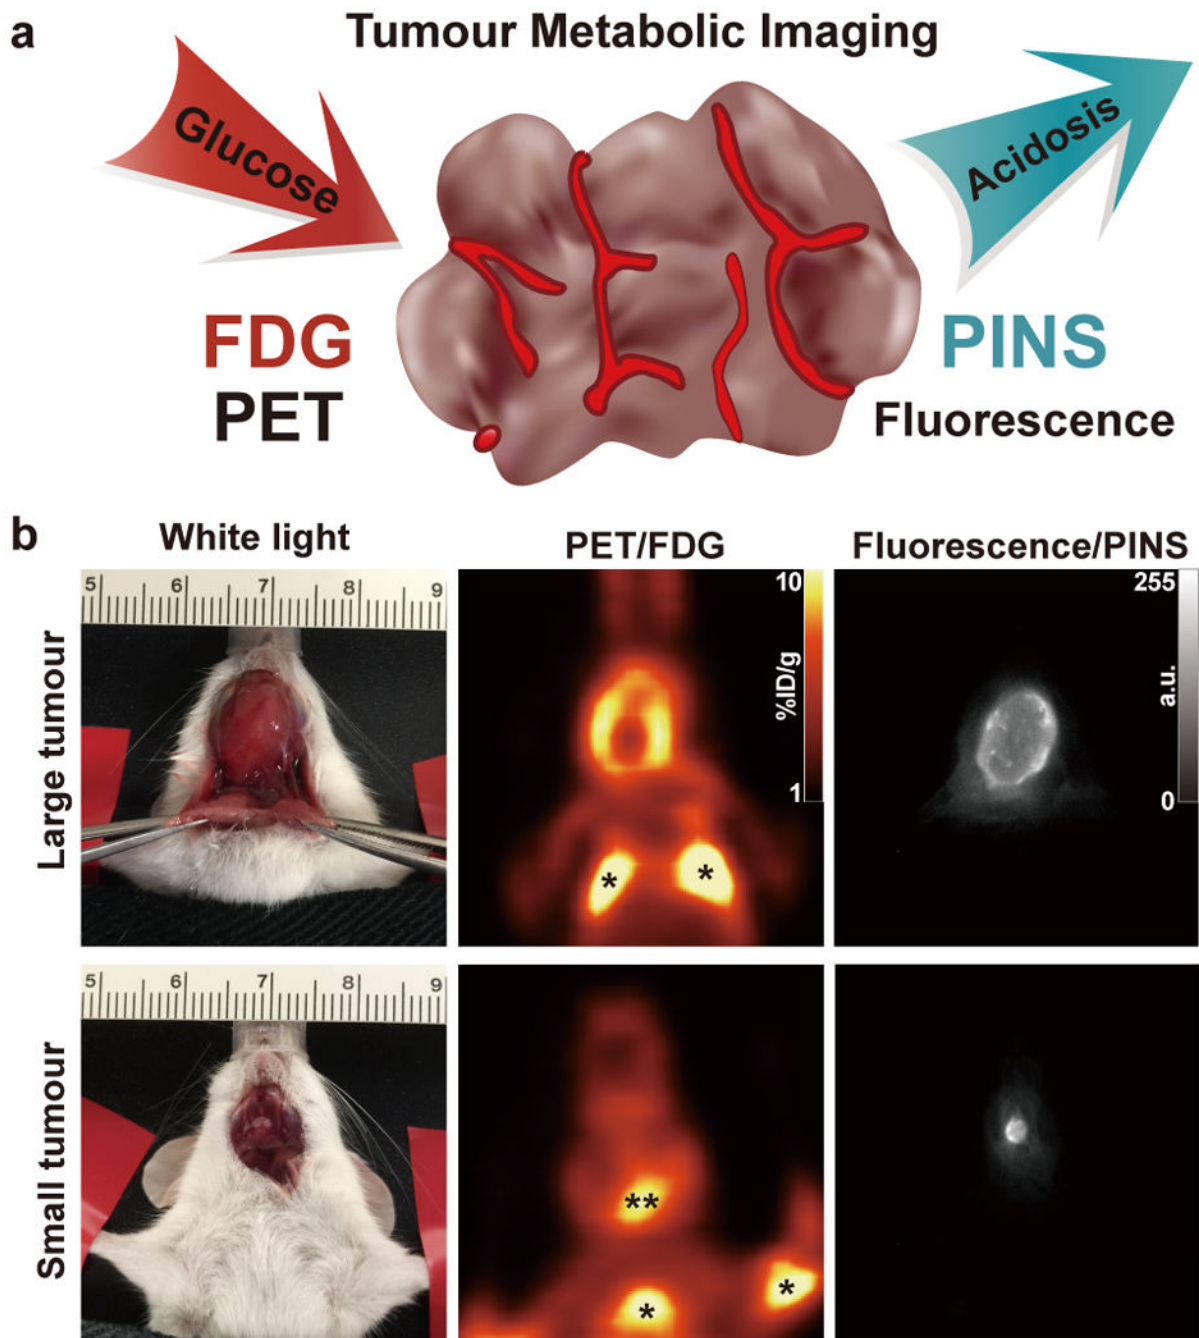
PINS improves cancer detection over FDG-PET
